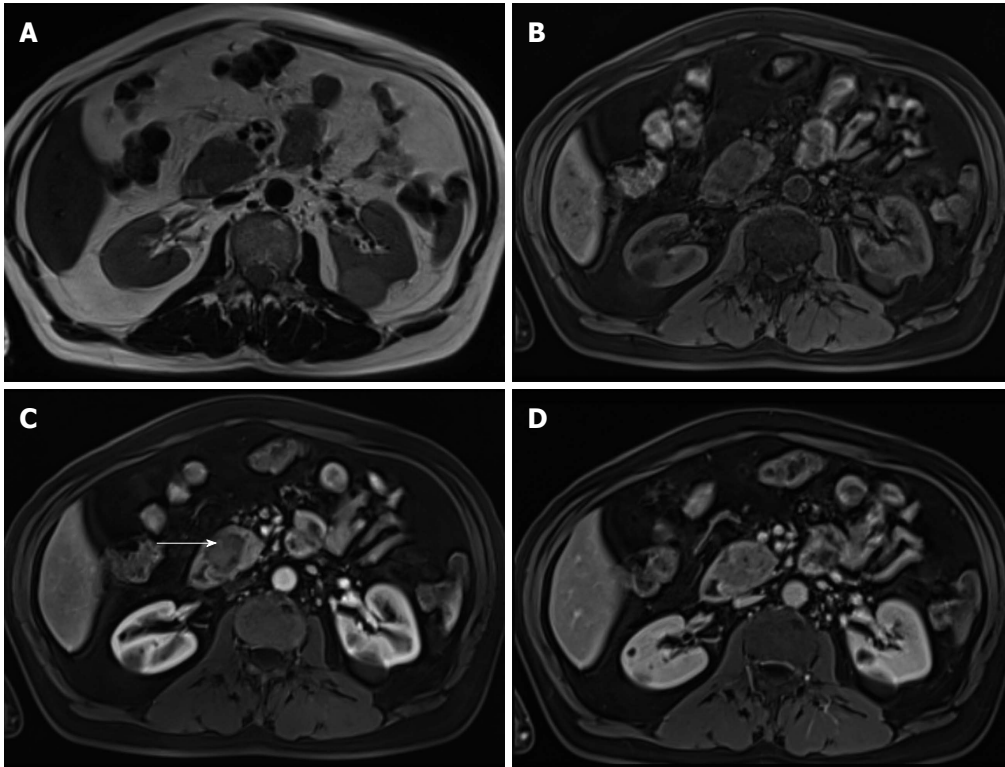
Pancreatic ductal adenocarcinoma. Axial T2-weighted single-shot echo train spin echo (A), pre-contrast fat-suppressed T1-weighted (B) gradient echo (GRE) and post-gadolinium fat-suppressed T1-weighted GRE images acquired in the arterial (C) and venous (D) phases of enhancement. There is a solid nodule in the head of the pancreas, which is more conspicuous in the pre-contrast and arterial phase T1-weighted images (B, arrow, C), consistent with ductal adenocarcinoma. Note that this lesion might be imperceptible on T2-weighted images (A) and venous phase images (D).
